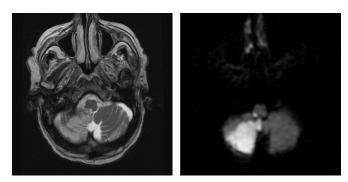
Stroke in the territory of the right posterior-inferior cerebellar artery in an 85-year-old man with biopsy-proven GCA (T2- and diffusion-weighted MRI sequences).
